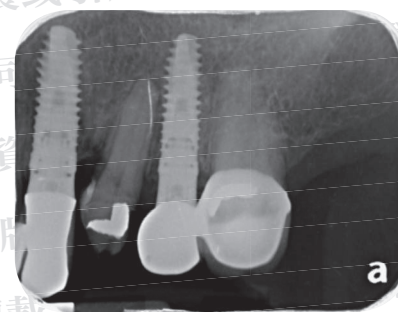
Periapical radiograph after crown removal of tooth #24 on September 23, 2015.
